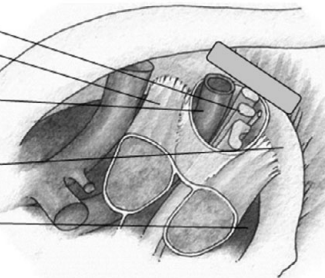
Supraclavicular block anatomy. Reproduced with permission from Arthurs G, Nicholls B (eds.) 2016. *Ultrasound in Anesthesia, Critical Care, and Pain Management*. Cambridge, UK: Cambridge University Press
